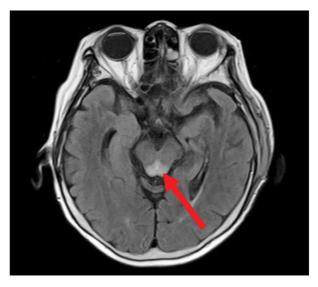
Magnetic resonance imaging shows characteristic Wernicke's encephalopathy with T2 signal hyper-intensity in the periaqueductal area (arrow).
